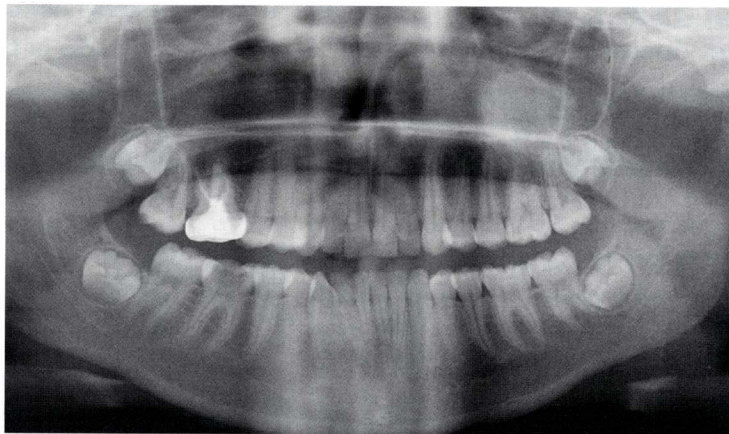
Panoramic radiograph showing a well-defined dome-shaped radiopaque lesion attached to the floor/wall of the left maxillary sinus.
